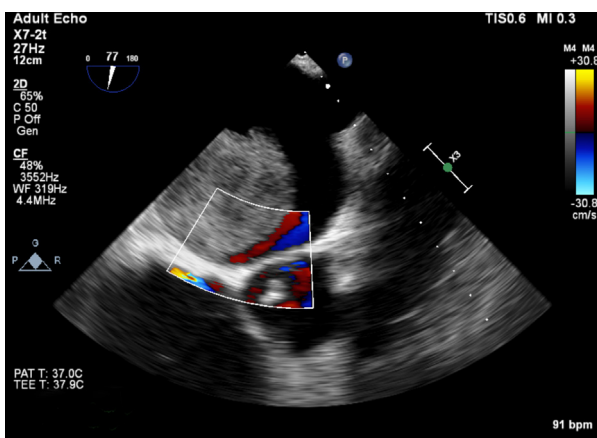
Modified midesophageal aortic valve short-axis color Doppler transesophageal echocardiography view obtained during mid-diastole showing a right-to-left atrial shunt (red) tracking along the anterior-superior border of the left atrial mass.
